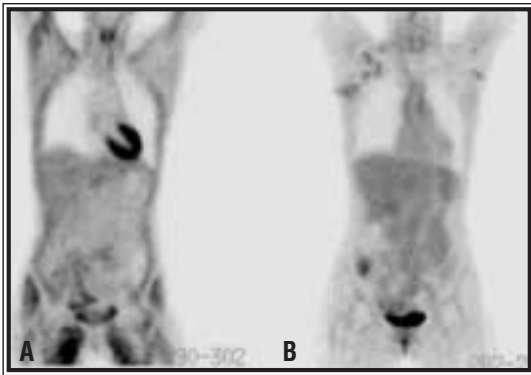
54-year-old woman with recently diagnosed breast cancer, referred for staging with FDG-PET. Despite being informed about minimizing or eliminating carbohydrates prior to her study, she had consumed several glucose-containing soft drinks shortly before the scan was obtained. A: Note the marked increase in muscle (cardiac and skeletal). B: A repeat FDG-PET done 48 hours later demonstrates multiple abnormal axillary foci and markedly reduced muscle and soft-tissue activity. Patient preparation is critical in optimizing lesion detection.
